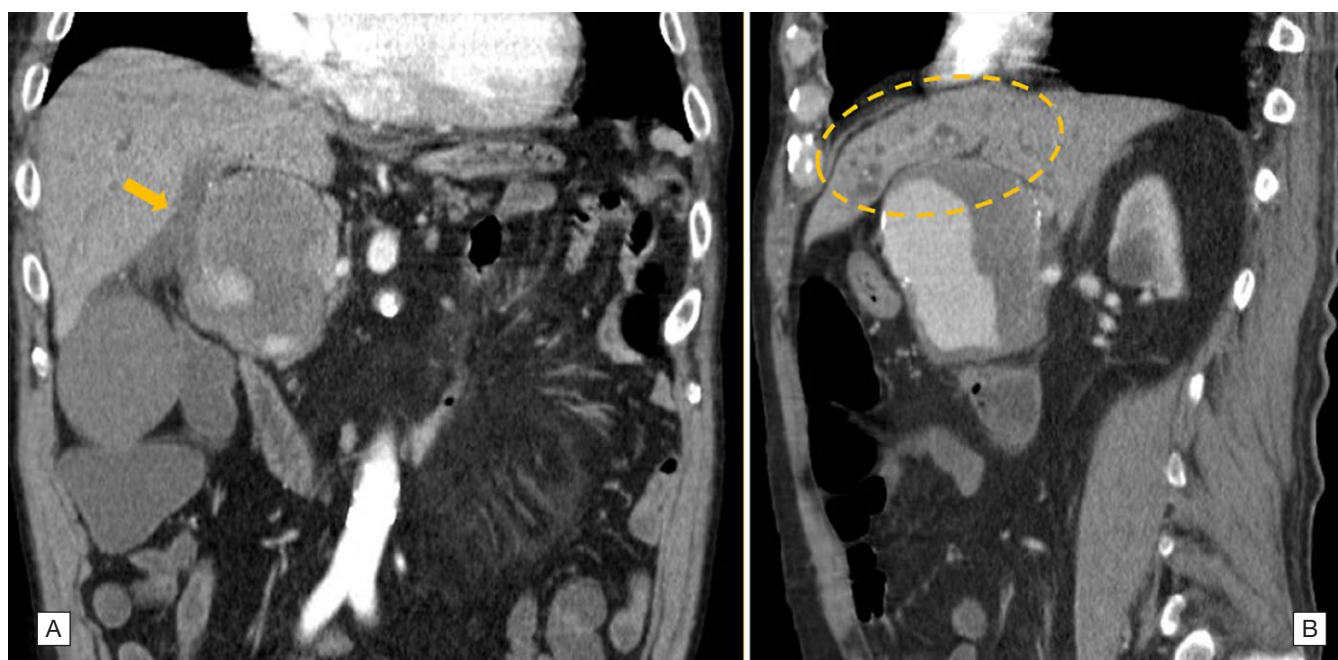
[A] - Coronal computed tomography scan – compression of the common bile duct (arrow). [B] - Sagittal computed tomography scan – dilation of intrahepatic bile ducts.
